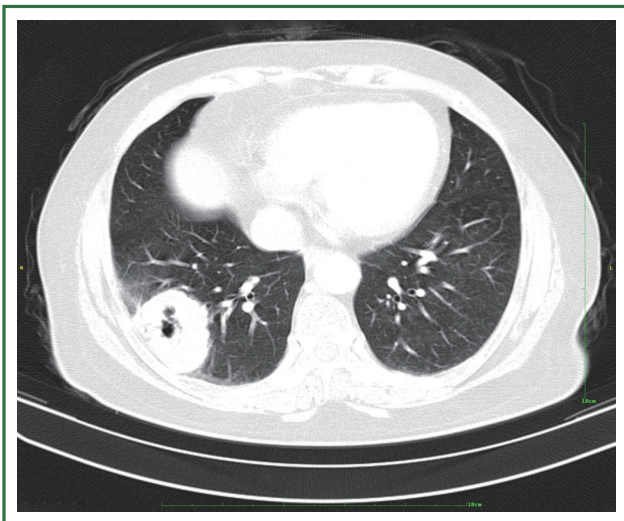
Axial chest CT shows a right lower lobe lesion on lung window.
